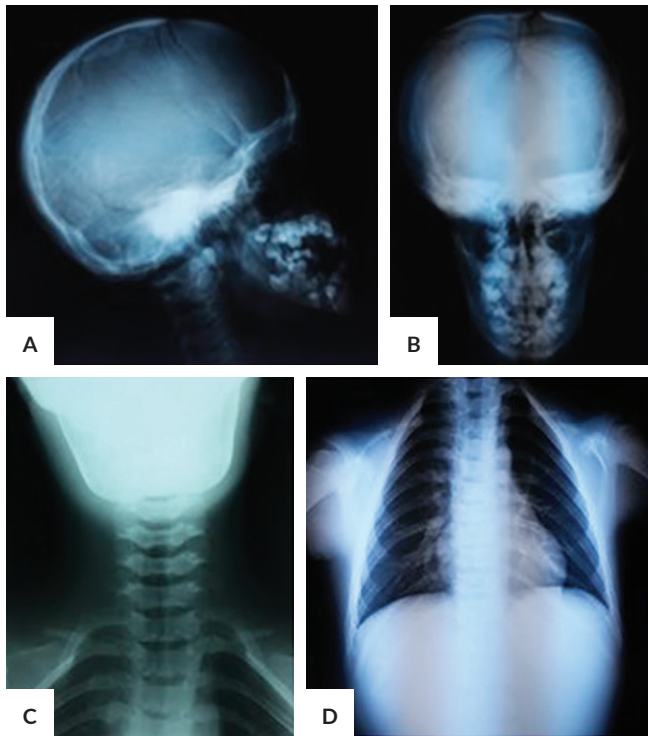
(A and B) Open sutures, multiple wormian bones, patent fontanels, hypoplasia of the maxilla, and dental crowding; (C and D) Hypoplastic clavicles and cone-shaped thorax on radiograph.
